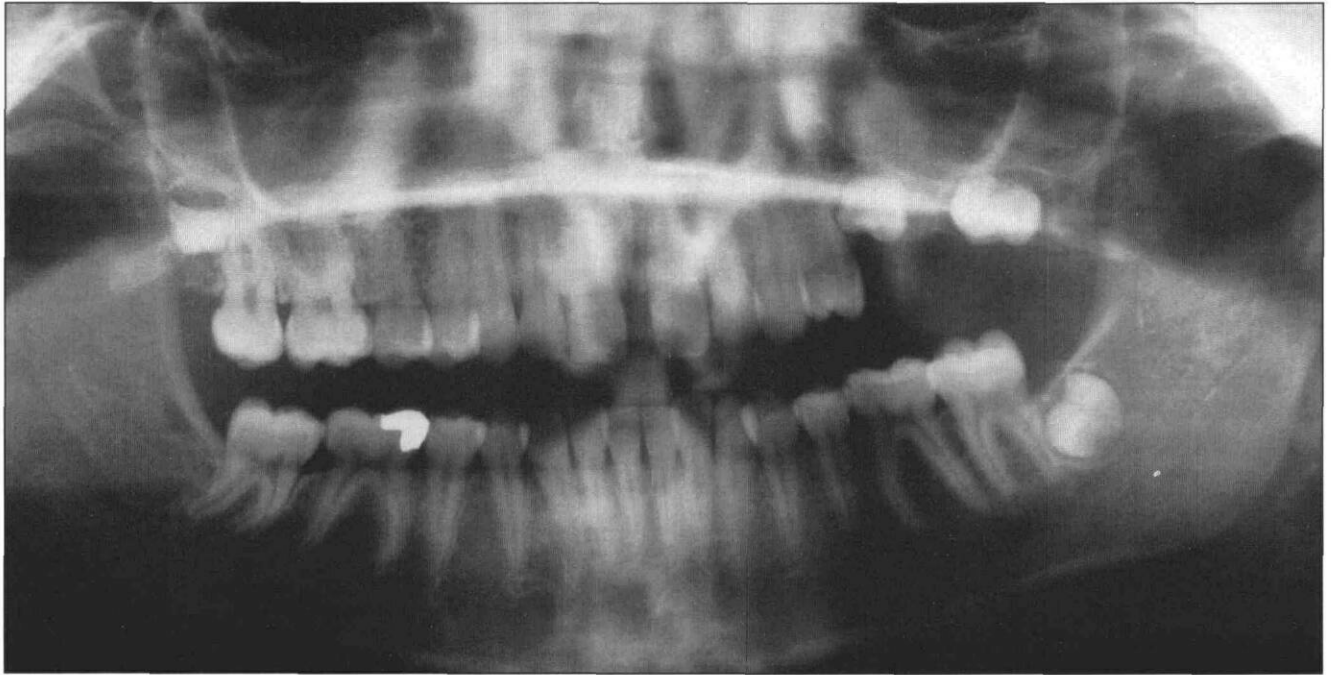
Panoramic radiograph of patient taken approximately 6 months after initial examination, confirming the arrest of root development of the maxillary left second premolar and second permanent molar. The surrounding bone appeared normal. The maxillary left first permanent molar had been extracted.
